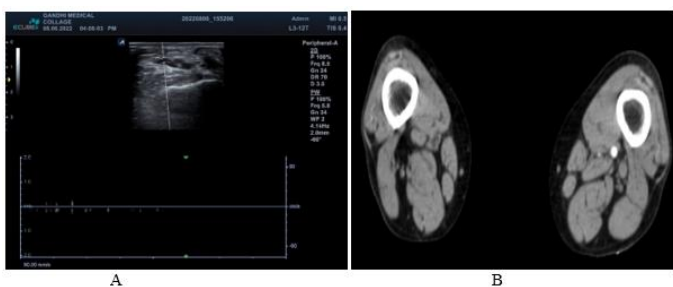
52-Year-old, diabetic, came with acute right leg pain at rest (A) Colour doppler study shows heterogenous heteroechoic thrombus occluding lumen of right SFA with no colour flow, no spectral waveform (B) CT angiogram axial section shows filling defect in right SFA due to thrombus causing its complete occlusion (grade 4 stenosis), Left SFA shows normal contrast opacification.
